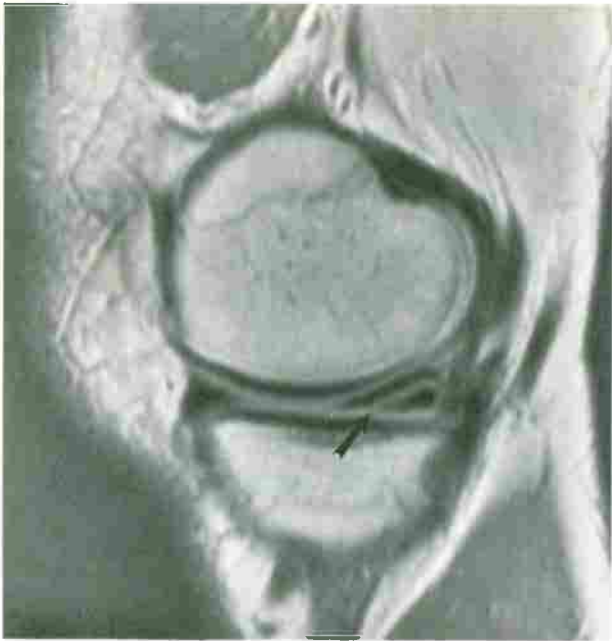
Horizontal meniscal tear. Sagittal T1-weighted (TR/TE, 800/20) image demonstrates high-signal-intensity line extending to the inferior articular surface of the posterior horn of the medial meniscus (arrow), representing a horizontal cleavage tear.
